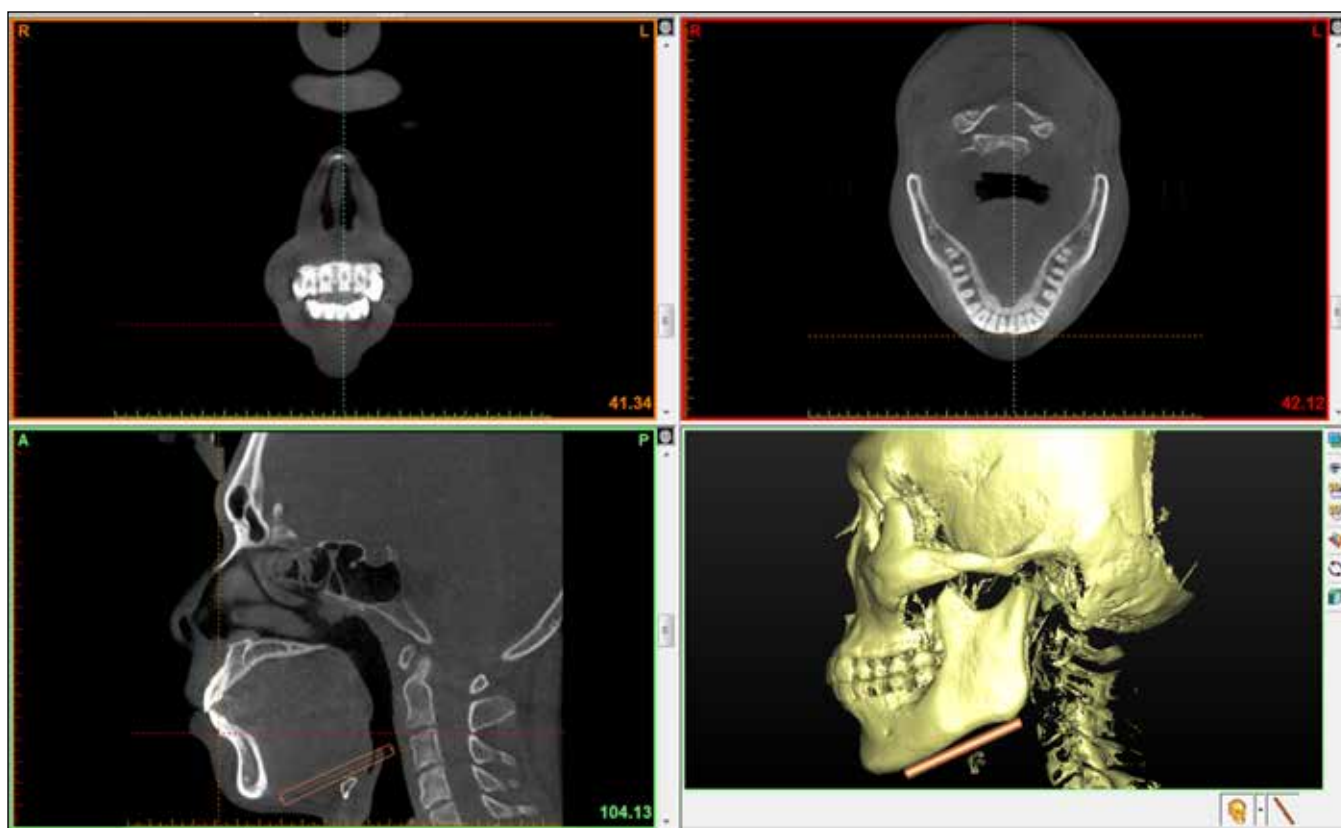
Four panel windows with coronal, sagittal, and axial slices of a C-mode CBCT image. A red reference box drawn parallel to the mandibular plane was used to define the boundary between the alveolus and basal bones in the mandibular symphysis.
